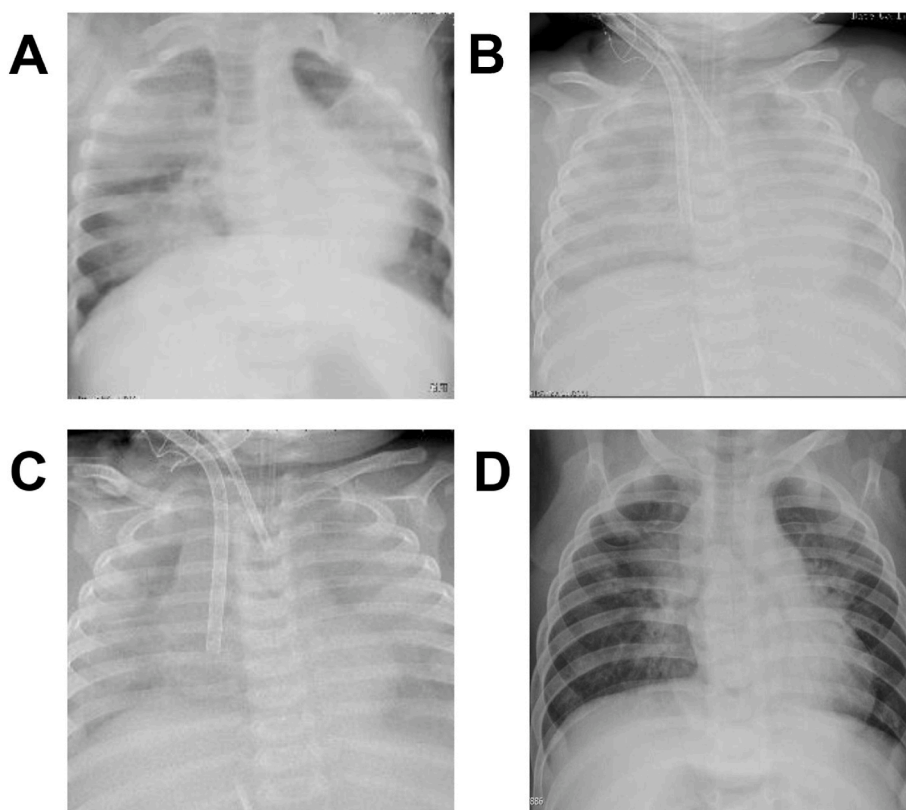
Patient 1 Chest X-ray
